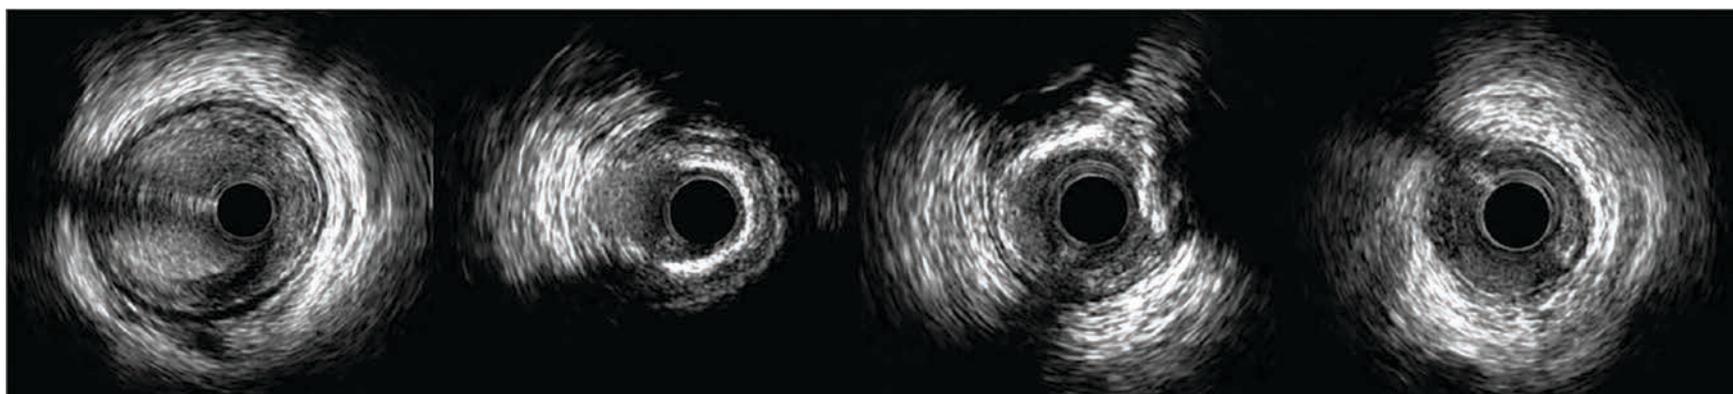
Intravascular ultrasound (IVUS) of RCA following rotational atherectomy. Ostial and proximal vessel reference diameter 3.75-4.0 mm, followed by heavy calcification in mid vessel occupying >270-degree arc, patent distal vessel without evidence of dissection.
